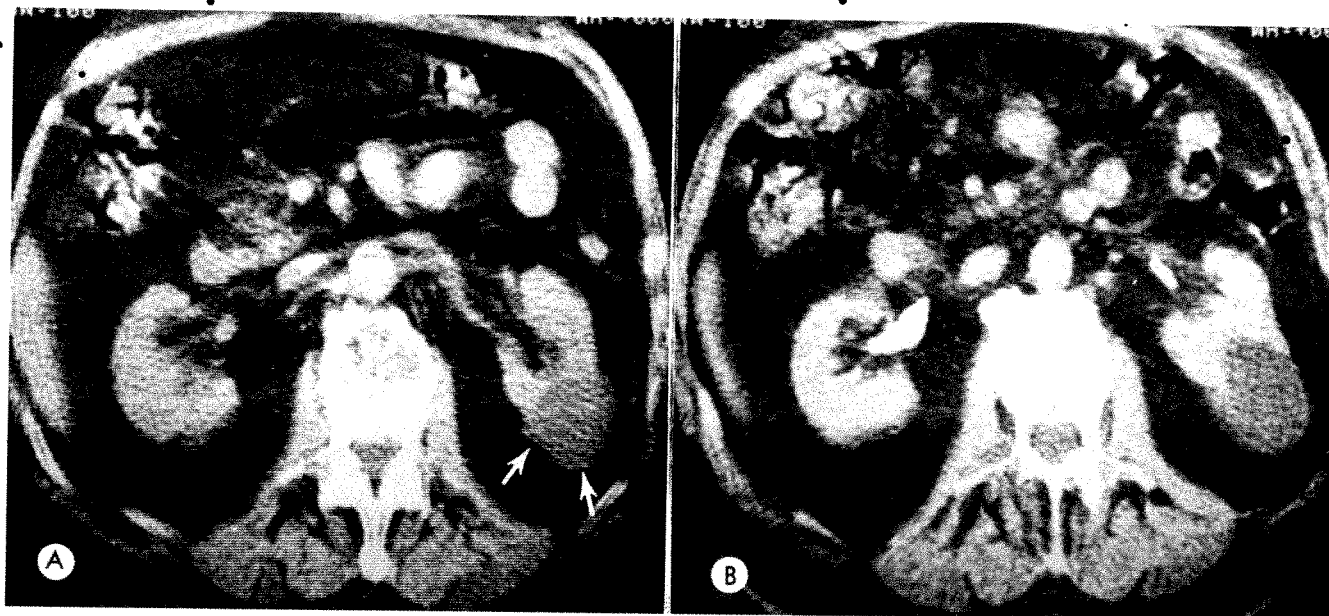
CT scans of markedly obese 60-year-old man without urinary tract symptoms. Urography demonstrated left renal mass; ultrasonography unsuccessful on two occasions to delineate nature of mass. A, Sharply demarcated smooth mass (arrows) of low attenuation (5 EMI units) characteristic of benign renal cyst. B, Enhancement of normal renal parenchyma after intravenous administration of 100 ml of Conray 400 without change in attenuation of cyst. Sharp demarcation between cyst and renal parenchyma maintained.
